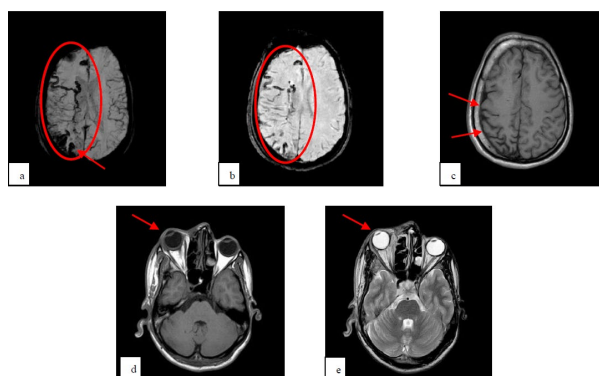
Magnetic Resonance Imaging- axial sections. (a) SWI imaging showing multiple 'black blood' vascular channels with blooming artifacts (red arrow). (b) VenoBOLD images showing multiple tortuous venous channels. (c) increase in calvarial thickness and reduced cerebral volume. (d) T1 weighted image showing proptosis. (e) T2 weighted image showing proptosis.
